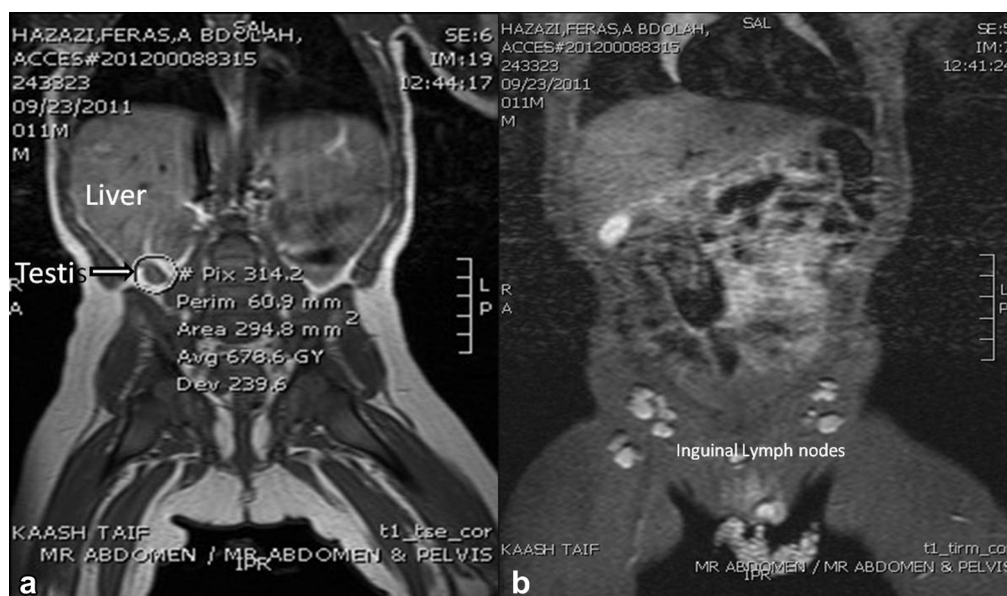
(a & b) MRI of abdomen and pelvis. (a) Empty right hemiscrotum. An intra-abdominal well circumscribed hyper intense structure seen in T₂W₁ measuring 4 × 5 mm which may represent the right testis at the right inguinal region. The left testis is seen in the left hemiscrotum. (b) Bilateral inguinal lymph nodes.
